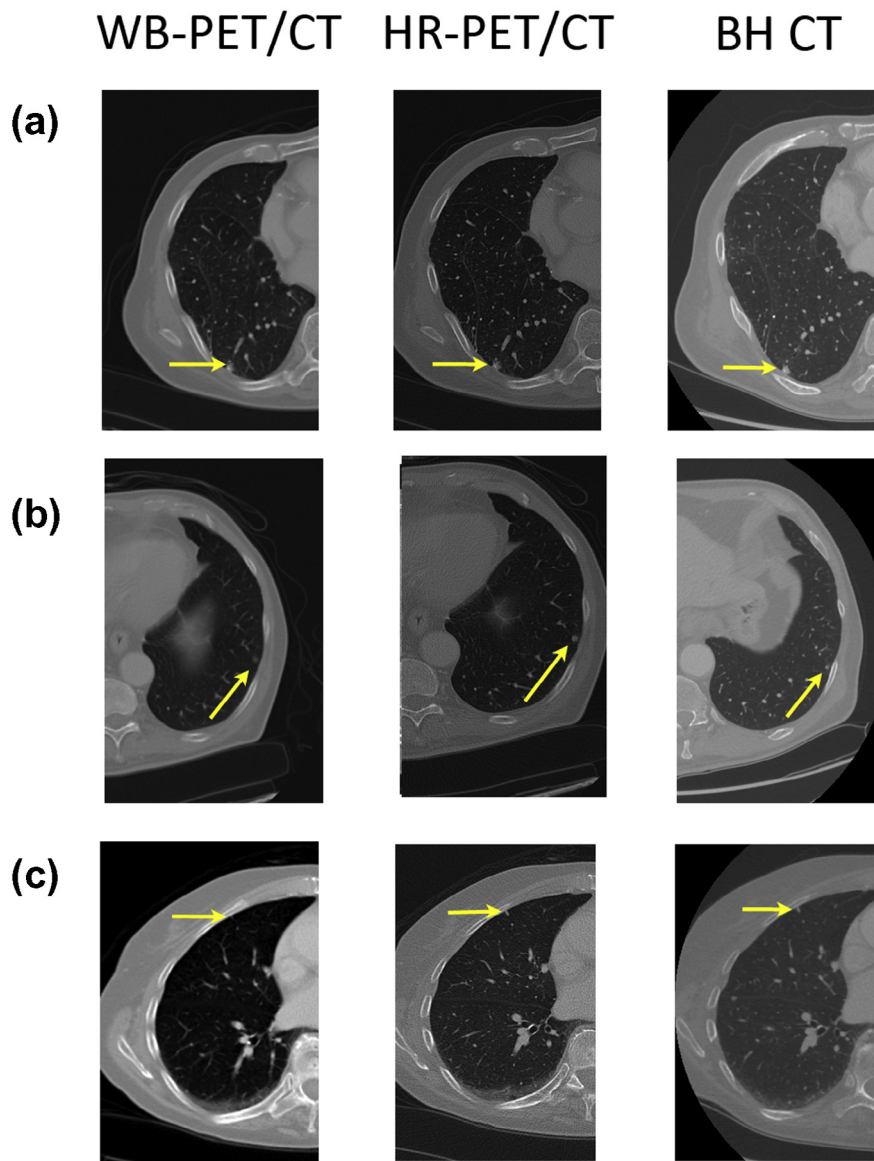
Examples of pulmonary nodules detected using various methods. (a) A 67-year-old man with history of non-small cell lung cancer (NSCLC) post-resection with a 4-mm nodule found along the suture line. The nodule was detected on whole body positron emission tomography/computed tomography (WB-PET/CT) by one out of three radiologists, on high-resolution PET/CT (HR-PET/CT) by three out of three radiologists, and on breath hold chest CT (BH-CT) by three out of three radiologists. (b) A 67-year-old man with history of NSCLC post-resection (same patient as [a]) with a 4-mm left lower lobe pulmonary nodule. The nodule was detected on WB-PET/CT by one of three radiologists, on HR-PET/CT by three out of three radiologists, and on BH-CT by three out of three radiologists. (c) A 78-year-old woman with history of NSCLC with recurrence. Images demonstrate a 3-mm subpleural right upper lobe nodule, detected on WB-PET/CT by none of three radiologists, on HR-PET/CT by two out of three radiologists, and on BH-CT by two out of three radiologists.
